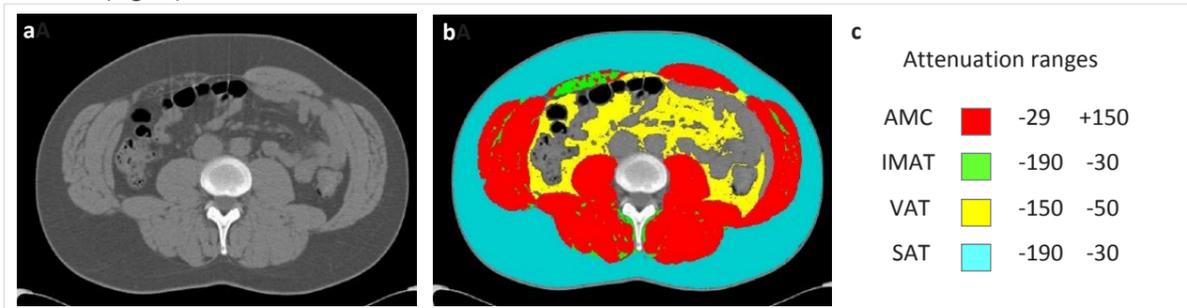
a) Single CT slice, b) Body composition segmentation c) Attenuation ranges.
